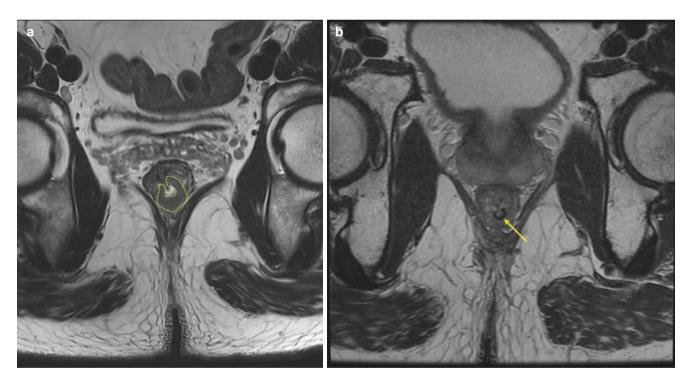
MR complete response. Radiological assessment of tumor response to nCRT. Posttreatment axial T2-weighted images indicate the presence of a low-signal-intensity area (a) at the site harboring the original tumor at baseline (b)
